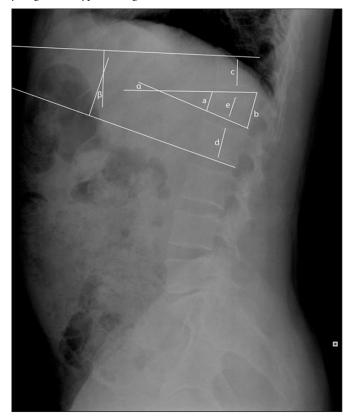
Representation of radiological parameters on the lateral radiograph. α : vertebral kyphosis angle (angle between the fractured vertebral body's upper and lower end plates). β : segmental kyphosis angle (angle between the upper end plate of the vertebral body above and the lower end plate of the vertebral body below the fractured body)
